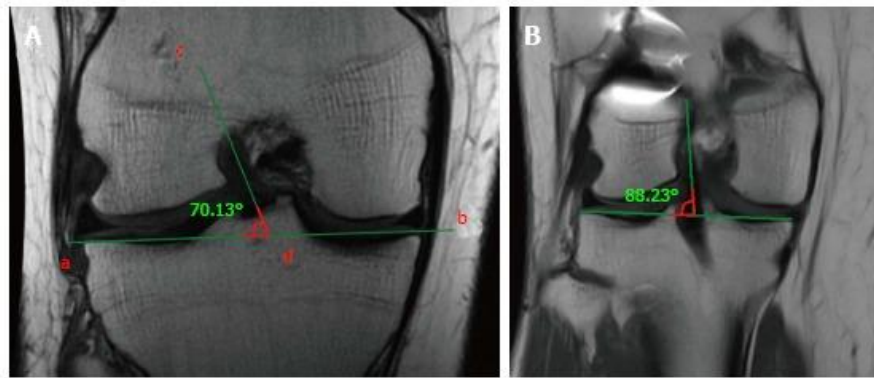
Coronal MRI images showing the correct position of both tibial and femoral tunnels of the ACL graft (*Quoted from Ladvas et al., 2012*).
